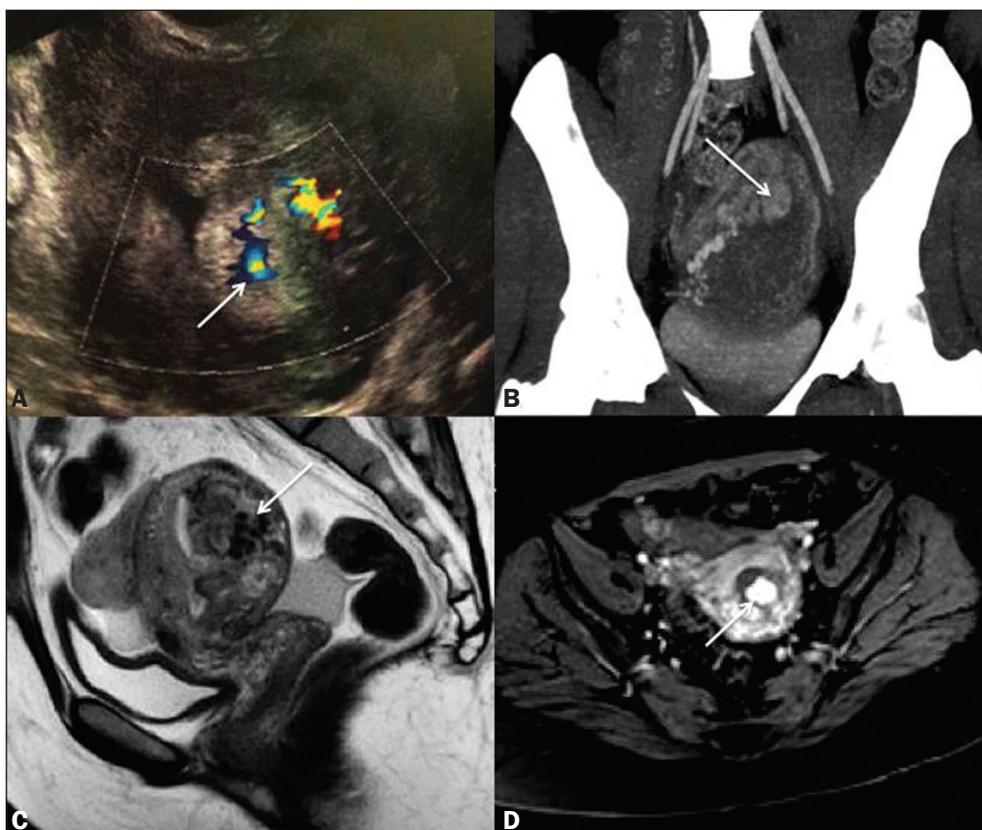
A: Transvaginal ultrasound showing a heterogeneous endometrial echo, with flow seen on the color Doppler study, especially in a grossly nodular formation in the basal region (arrow). B: Contrast-enhanced CT scan with maximum intensity projection reconstruction identifying prominent myometrial and periuterine vessels in communication with the hypervascularized nodular area (arrow). C,D: Contrast-enhanced MRI scans (sagittal T2-weighted and axial T1-weighted sequences, respectively) confirming the marked vascular dilatation, characterized by a flow void in the posterior uterine wall (arrow in C) and intense vascularization of the basal nodule (arrow in D).
